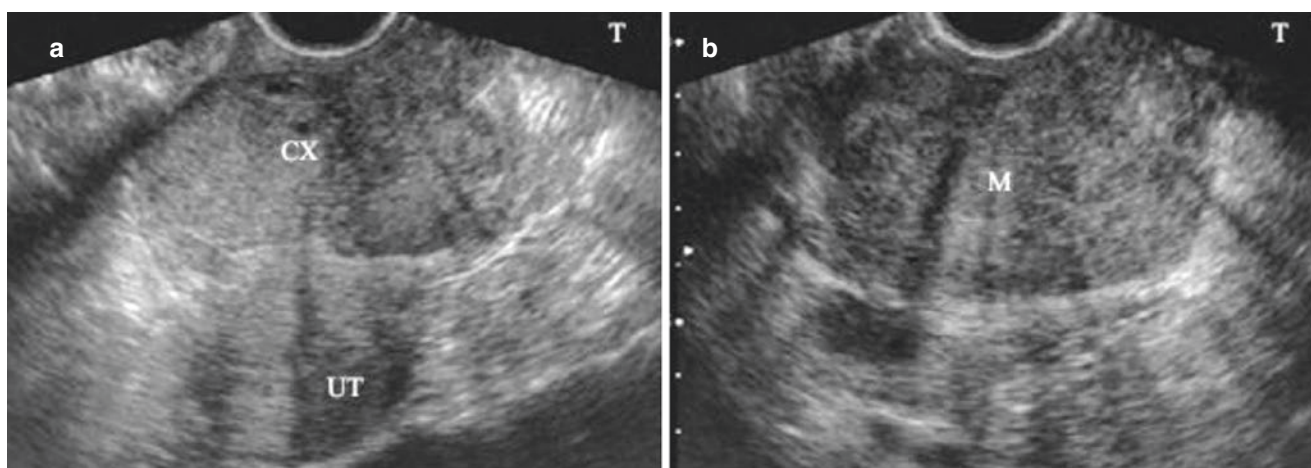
Cervical cancer (II). A 59-year-old patient with a postmenopausal period of 7 years represented vaginal bleeding for 3 months. (a) Ultrasonic images show atrophic corpus, abnormal cervical morphology, and an irregular mass with a diameter of about 7.0 cm. (b) Transverse images show the mass of the same patient
